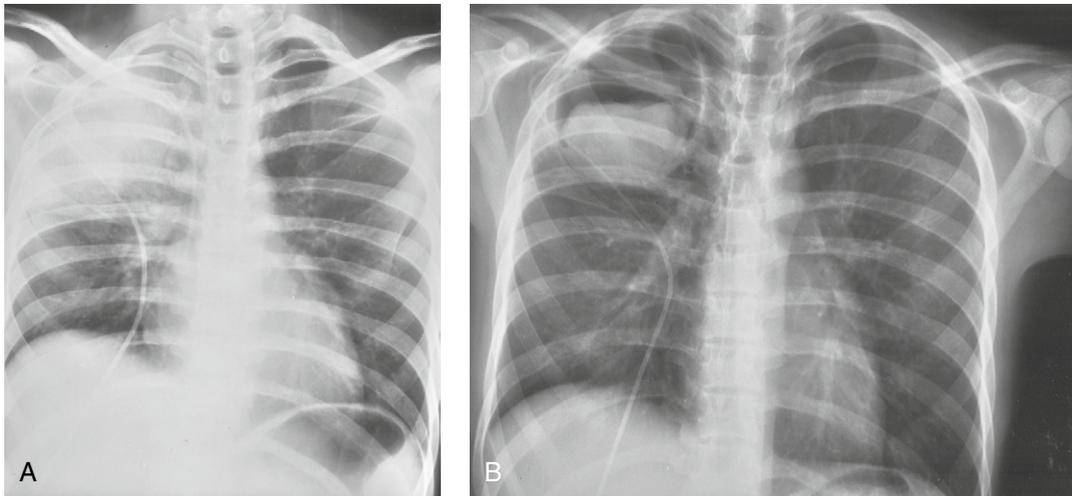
Zygomycosis in an 18-year-old man with acute lymphocytic leukemia who had just completed the first 7-day course of chemotherapy. He complained of increasing lethargy, night sweats, anorexia, weight loss, anemia and leukopenia. (A) PA chest radiograph demonstrates a large area of airspace consolidation in the right upper lobe. Sputum culture grew *Klebsiella* but the patient did not respond well to aggressive antibiotic therapy. Right subclavian vein central line is present. (B) Follow-up PA chest radiograph 2 months later demonstrates a large right upper lobe cavity with a dependent ovoid mass. Bronchoscopy recovered *Rhizopus* species.
